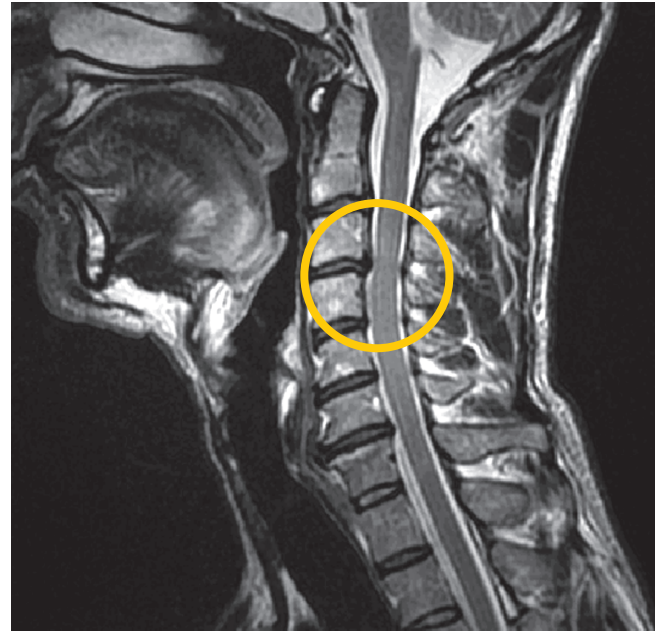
MRI of cervical vertebrae and cervical spinal cord
